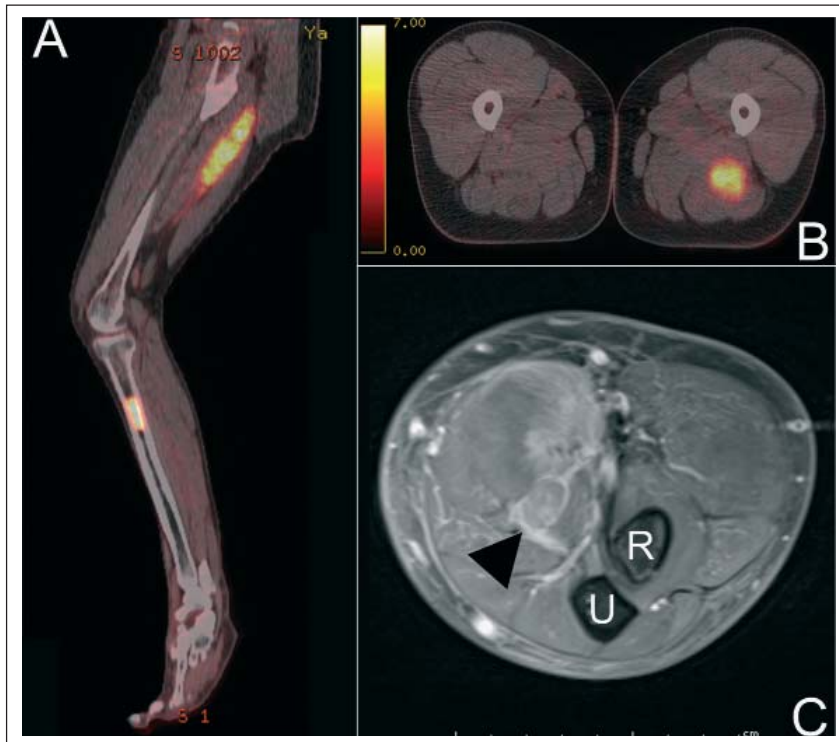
A 54-year-old man with a history of mantle cell lymphoma presented with tingling along the palmar surface of his left thumb. Then the left thumb, first and second digit started feeling “inflamed, swollen, about to explode”. The pain awakened him at night. At the same time, he felt a burning pain along the heel, lateral and anterior plantar surface of the right foot. Work-up revealed neurolymphomatosis. Multiple mass lesions were identified within the peripheral nervous system including the left sciatic nerve (a, b) 18-FDG-PET), the left median nerve (arrow head in c); axial T1-weighted MRI of the left forearm; note infiltration of the flexor musculature by tumour), right brachial plexus, right sciatic nerve, and left tibial nerve (not shown). Biopsy of the soft tissue mass in the right forearm revealed a mantle cell lymphoma.
